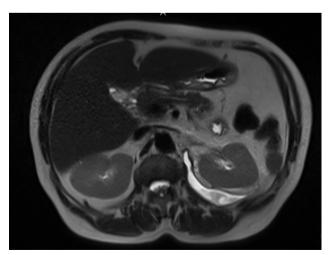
Control magnetic resonance imaging after insertion of a left nephrostomy catheter, and antegrade JJ stent.
